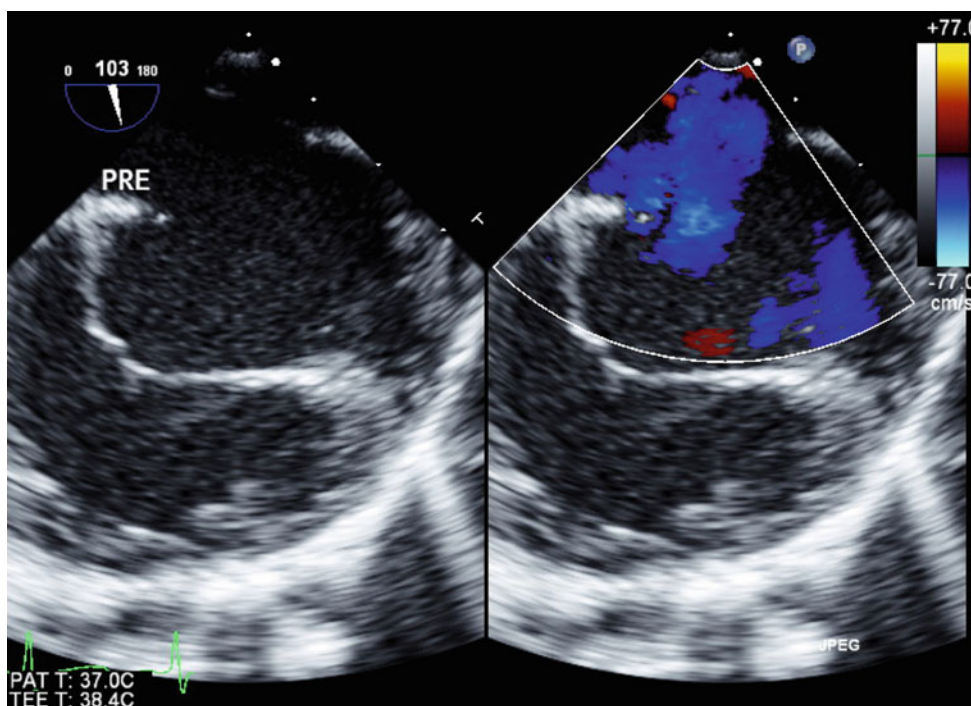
Images demonstrate a high secundum atrial septal defect in the mid esophageal bicaval view (*left panel*) and corresponding color flow Doppler (*right panel*)
